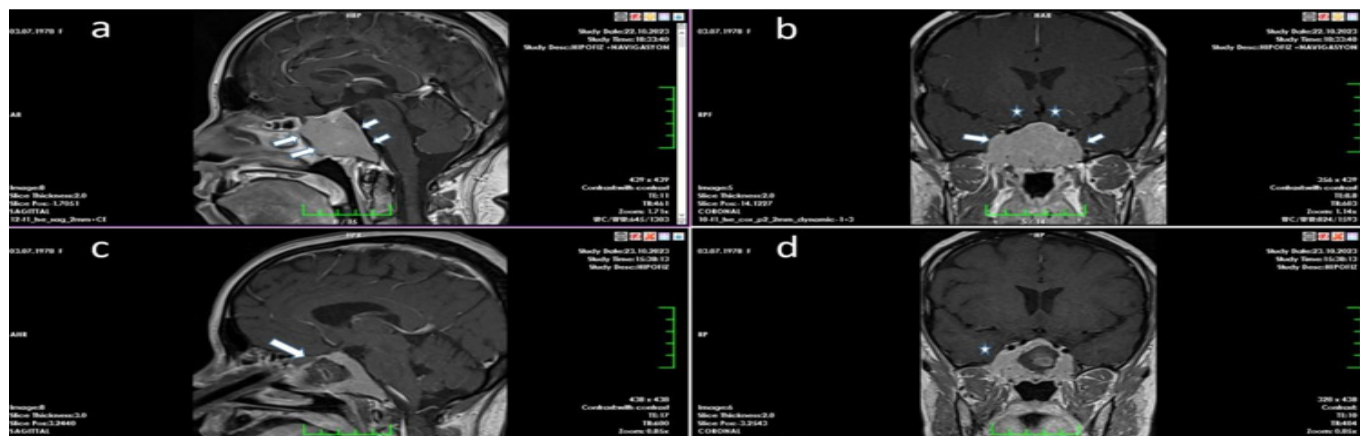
(a,b): Preoperative sagittal and coronal sections contrast-enhanced MRI, (c,d): postoperative sagittal and coronal sections contrast-enhanced MRI
